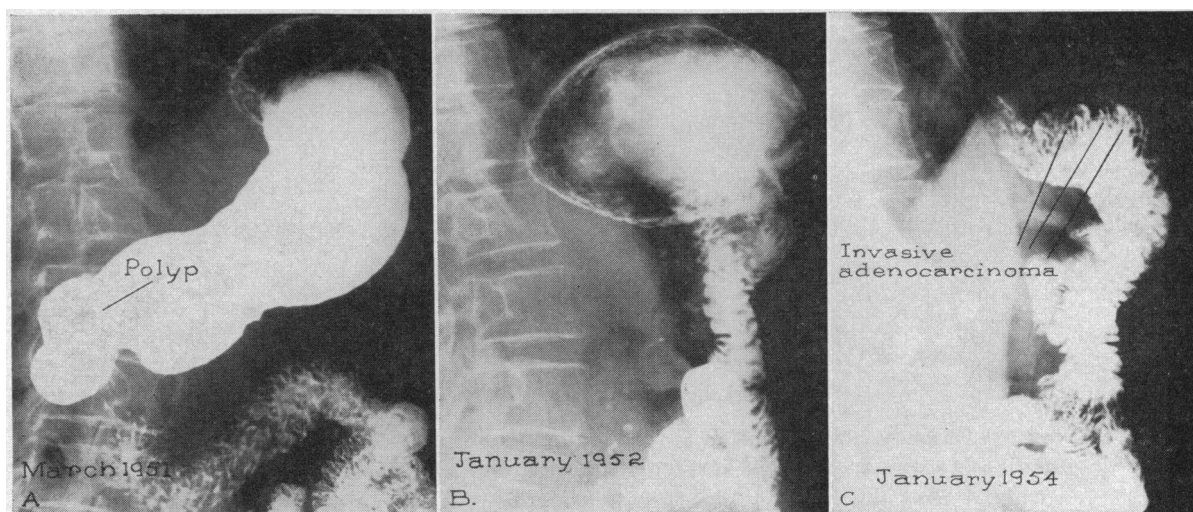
Roentgen studies indicated a polyp in the prepyloric area. At operation a polyp high in the stomach (A) was electrocoagulated. Follow-up studies a year later showed no apparent disease. A well-functioning gastroenterostomy was present. (B) Obstructive symptoms developed three years after operation. (C) The entire gastric pouch was replaced by malignant disease.
